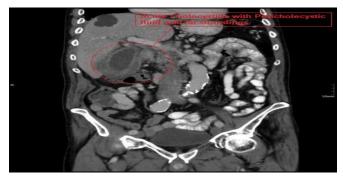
Contrast-Enhanced Computed Tomography of Abdomen showing Acute
